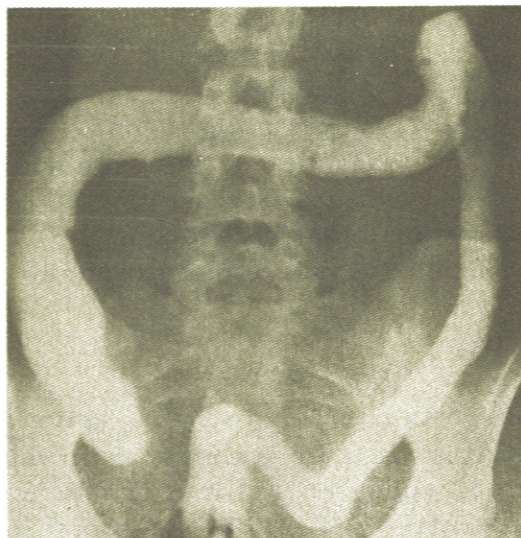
Roentgenogram of colon with evidence of ulcerative colitis.
